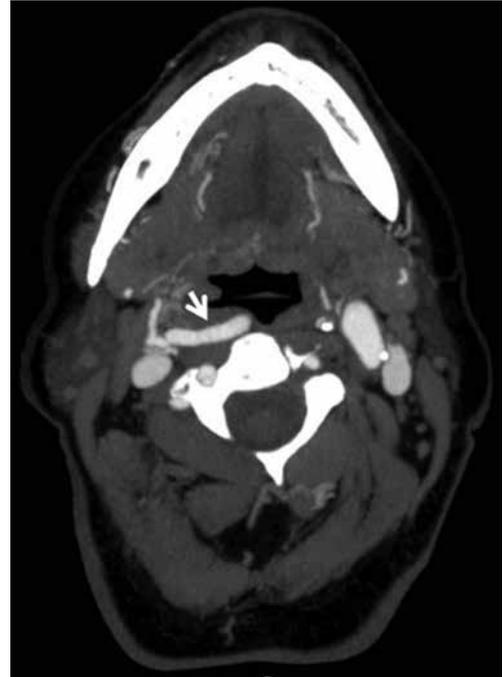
Computed tomography angiography retropharyngeal course of right internal carotid artery with hypopharyngeal imprint.
